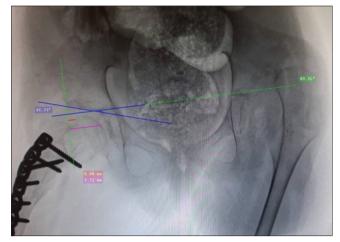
Post-operative radiograph in patient 2
